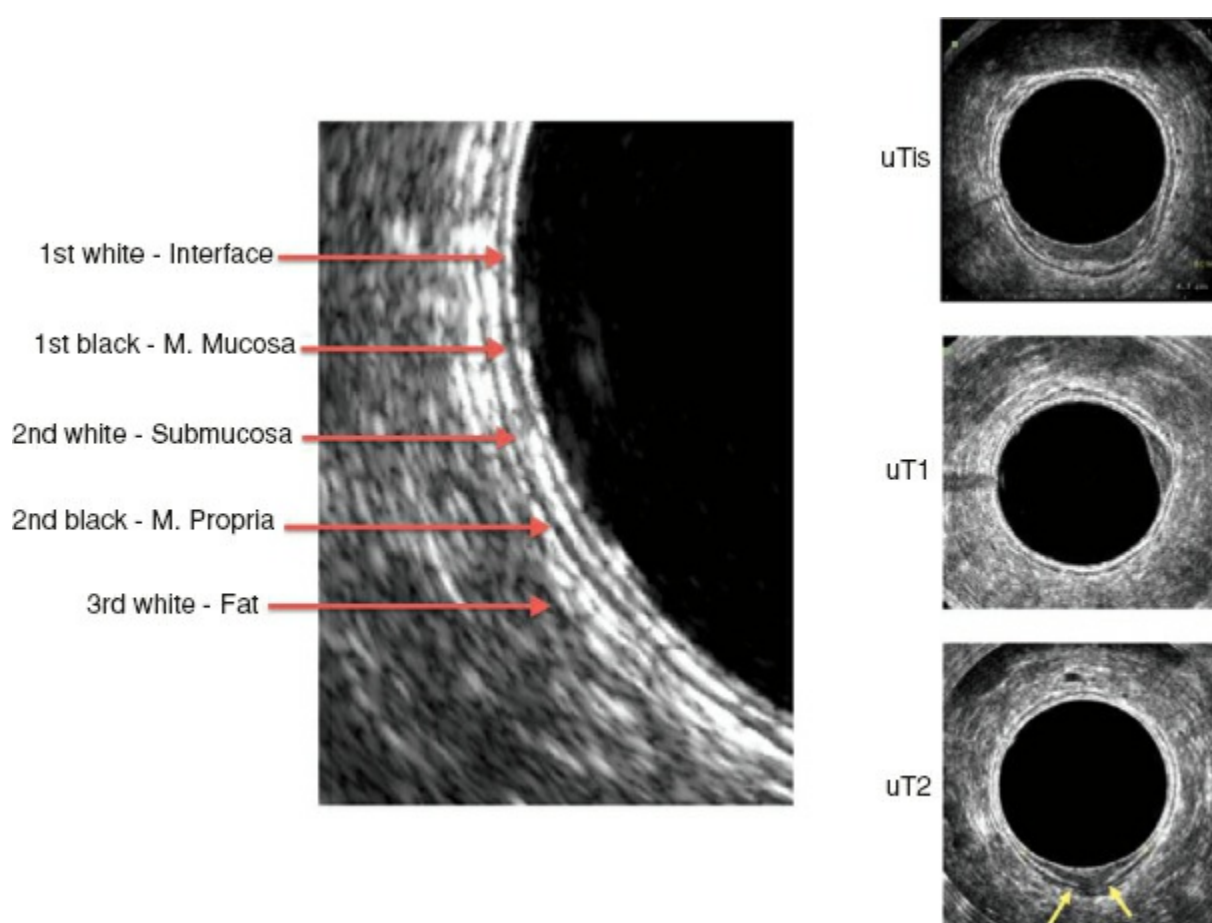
Endorectal ultrasound. Role in rectal cancer staging.
